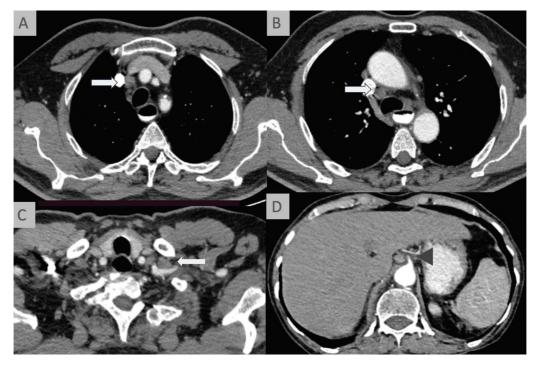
Lymph node metastases in esophageal cancer. (A and B) Axial contrast-enhanced computed tomography (CT) scan shows right upper paratracheal lymph nodal enlargement (arrows). (C and D) Axial contrast-enhanced CT scan shows enlarged left supraclavicular lymph node (arrows, C) and gastrohepatic lymph node (arrowhead, D).
